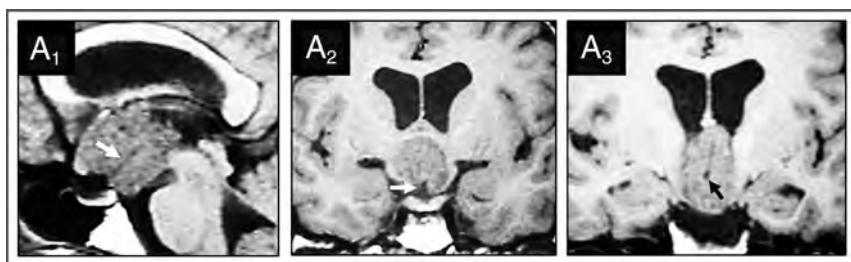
Basal recess in strictly 3V CPs of the papillary type: MR imaging evidence in 1 case identified from our series. Case 1 (Online Supplemental Data): This papillary CP was diagnosed in a 34-year-old woman with headaches, Fröhlich syndrome, poikilothermy, and emotional lability. Preoperative T1WI shows this strictly 3V homogeneously isointense lesion above the intact 3VF, with papillomatous excrescences at its surface. On the midsagittal (A_1) and coronal (A_2 , A_3) scans, a long basal recess can be identified as a tube-like hypointense structure extending from the suprasellar cistern to the center of the tumor (white arrows, A_1 and A_2 ; black arrow, A_3).
